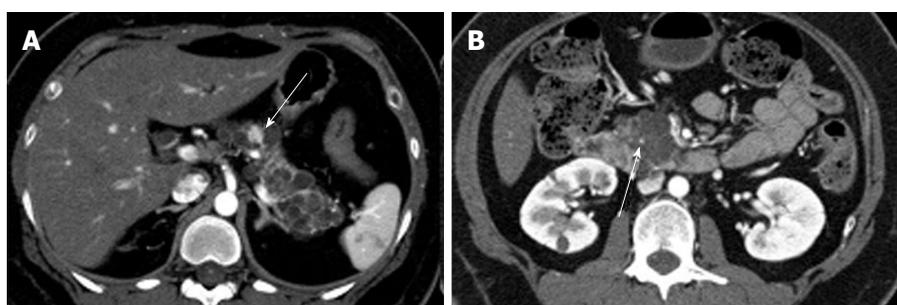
A 43-year-old female with von Hippel-Lindau disease. A: The arterial phase of an axial contrast enhanced-computed tomography demonstrates numerous cystic lesions in the body and tail of the pancreas. There is a solid hypervascular lesion in the pancreatic body (arrow), representing neuroendocrine tumor; B: A multilocular cystic lesion in the pancreatic head consists of a punctate central calcification (arrow) with microcystic (right side) and macrocystic (left side) components, representing serous cystic neoplasm.
